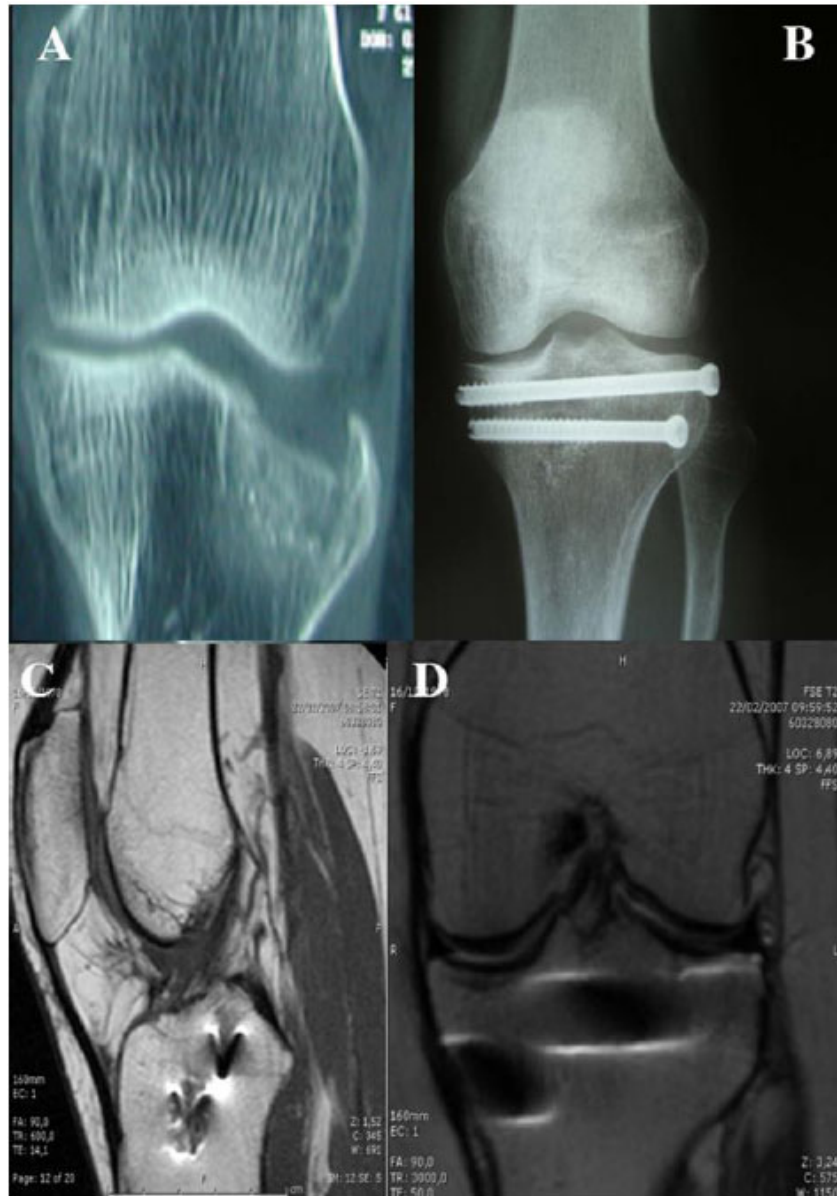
Preoperative CT scan (A), post-operative X-rays (B) and MRI (C and D) images of a Schatzker type III fracture treated with arthroscopic assisted reduction and internal fixation [courtesy of dr. Francesco Atzori, San Luigi Hospital of Orbassano, Italy].
